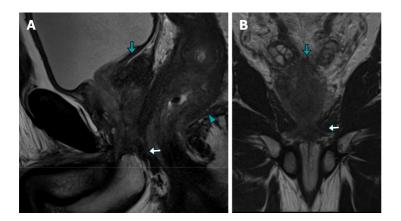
Magnetic resonance imaging images of case 2 demonstrating metastatic prostate adenocarcinoma. A and B: The sagittal (A) and Coronal (B) T2-weighted turbo spin echo images demonstrate diffuse neoplastic involvement of the prostatic parenchyma, with extension to the rectal wall (arrowhead), base of the seminal vesicles (green arrow), and external urethral sphincter (white arrow).
